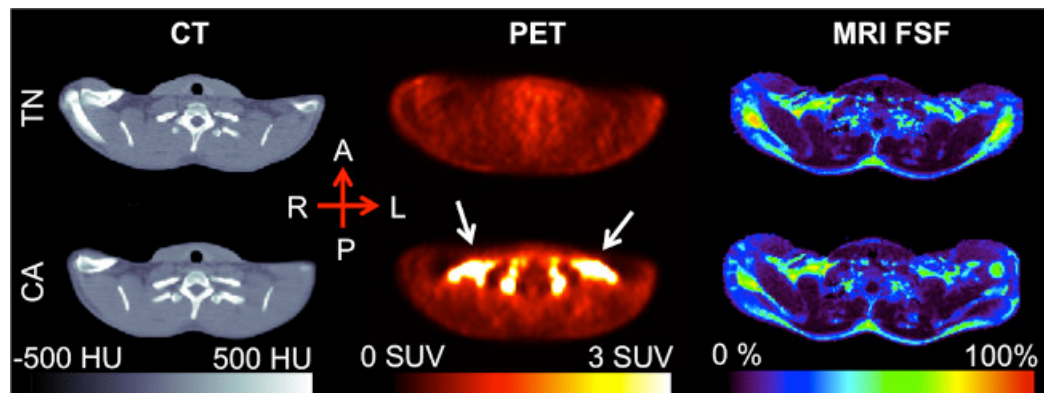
Clavicular-level axial slice, post-registration. The increased ^{18}F -FDG uptake seen in the CA PET scan (white arrows), occurs in the supraclavicular region of adipose tissue as determined by the CT Hounsfield Unit values. The MRI fat signal fraction (FSF) in this region falls in the 50-80% range, similar to that of previous research. [Please click here to view a larger version of this figure.](#)
